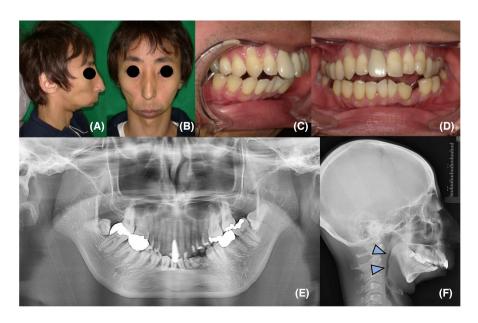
Findings at the initial visit. (A, B) Extraoral photographs (facial view): Severe mandibular retrognathia. (C, D) Intraoral photograph: An open bite. (E) Panoramic radiograph: Hypoplasia of the bilateral mandibular condyles and deviation of the condyle from the mandibular fossa. (F) Cephalometric radiograph: Severe upper airway stenosis.
